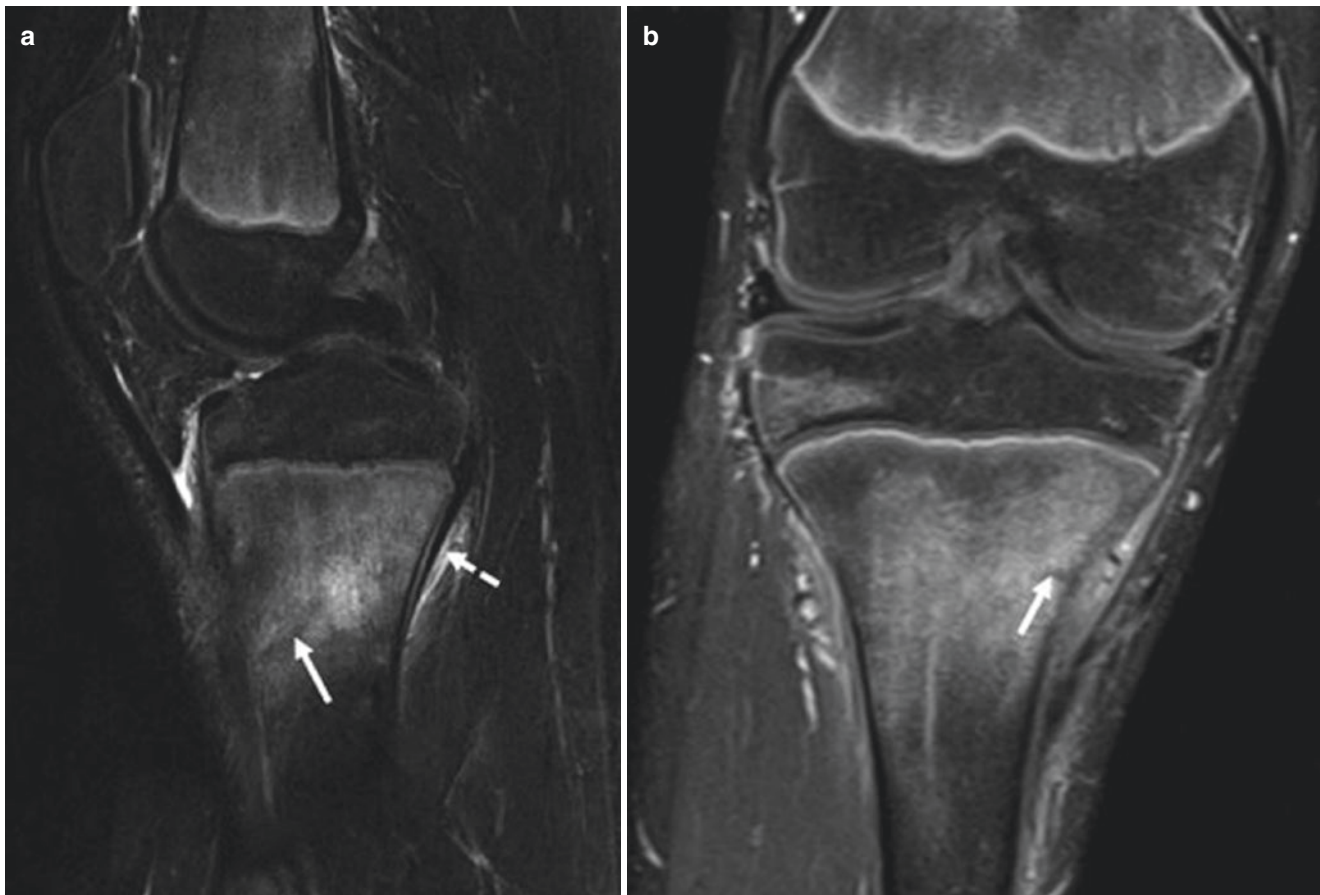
(a, b) Tibial stress fracture. Sagittal T2 fat-suppressed MR image (a) in a 14-year-old boy with proximal tibial pain in the setting of increased lacrosse training shows metaphyseal marrow edema with a subtle low signal intensity oblique line centrally (arrow) and posterior
